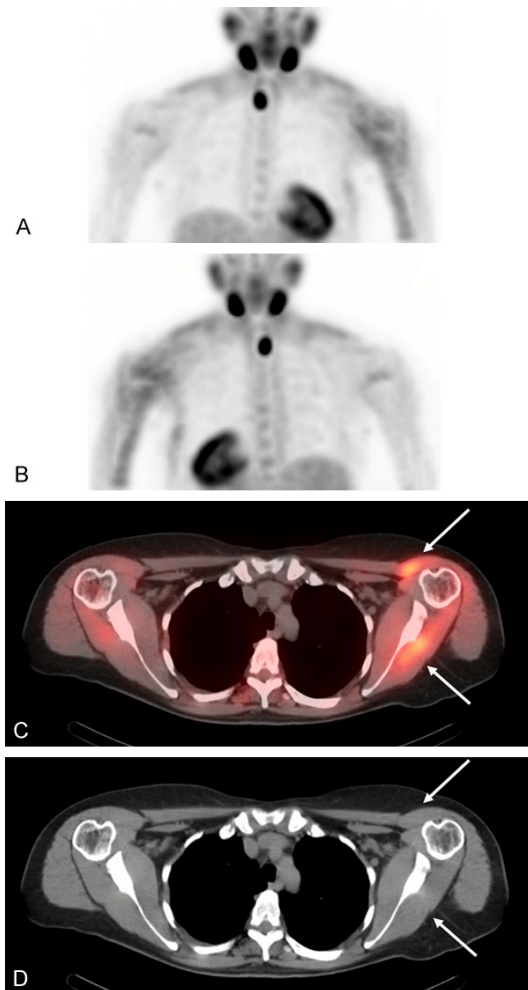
A-D. Anterior and posterior MIP images, axial SPECT/CT fused and CT only images.
